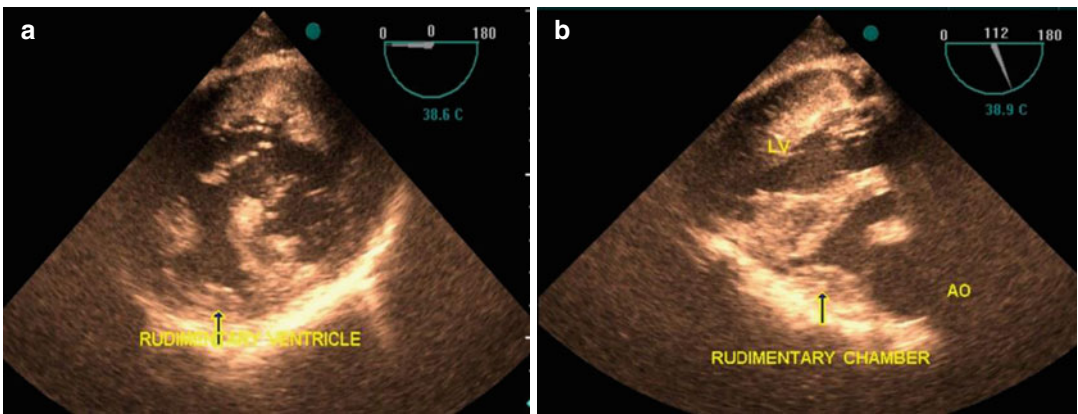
(a, b): Transesophageal echocardiography in transgastric short axis and long axis view showing main ventricle with LV morphology (DILV) and aorta that arises from the rudimentary anterior chamber. *AO* aorta, *LV* left ventricle
